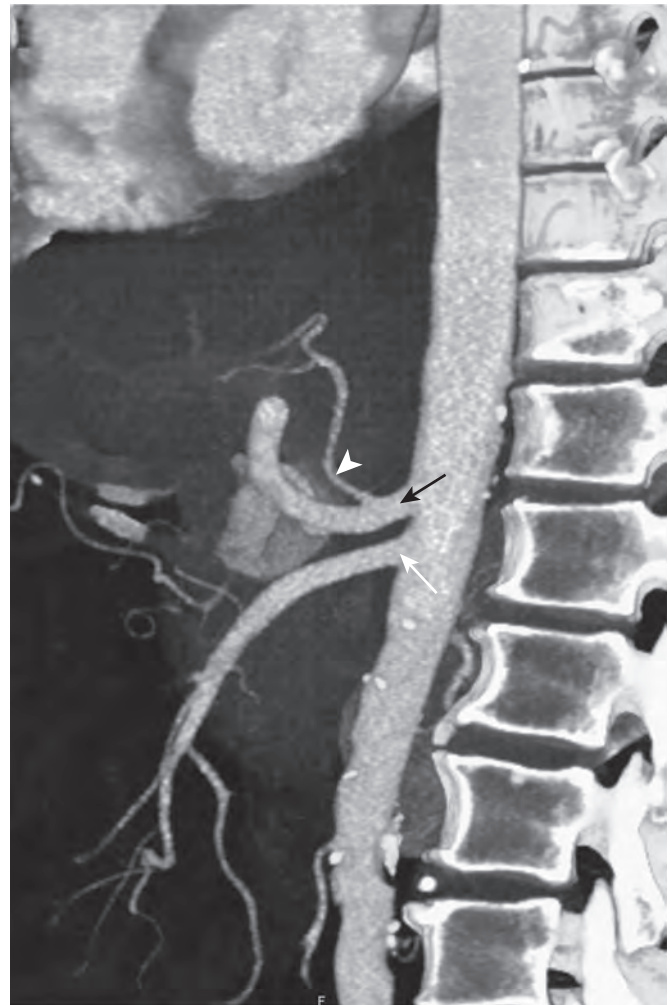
Normal celiac and superior mesenteric artery anatomy. Sagittal volume-rendered CT angiogram demonstrates normal anatomy of the celiac axis (black arrow) and superior mesenteric artery (white arrow). The left gastric artery (arrowhead) can also be seen arising from the celiac artery.
